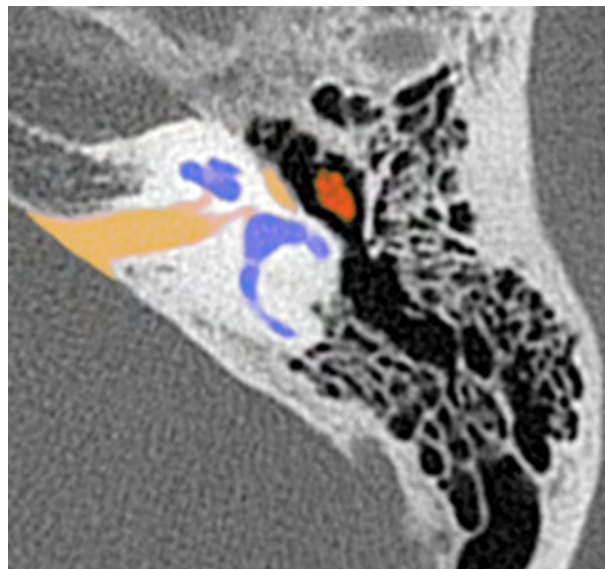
Colored CT image of normal left temporal-bone structures.
